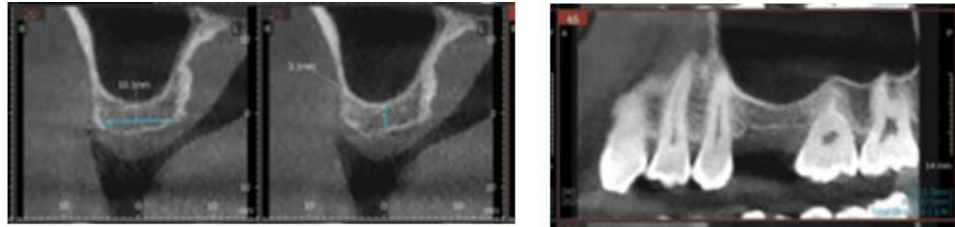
(a) CBCT revealed horizontal and vertical bone measurements, (b) CBCT revealed sinus pneumatization.
